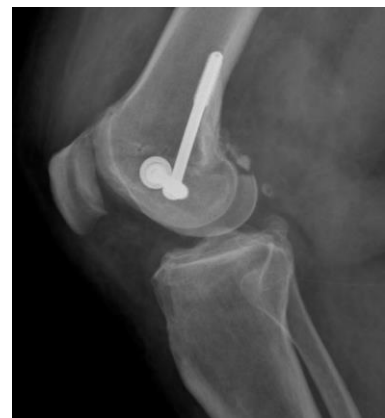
Post-operative lateral x-ray of the patient's knee showing anatomically-reduced fracture fixed with two 7.3 mm cannulated screws
